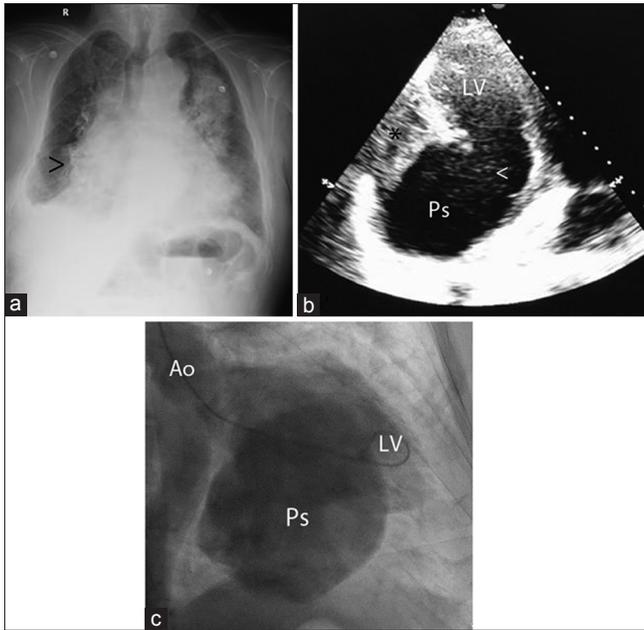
(a) Posteroanterior chest radiograph (b) Transthoracic echocardiogram in the apical two-chamber view (c) Left ventricular angiogram in the right anterior oblique projection. Ps: Pseudoaneurysm, LV: left ventricle, Ao: aorta
